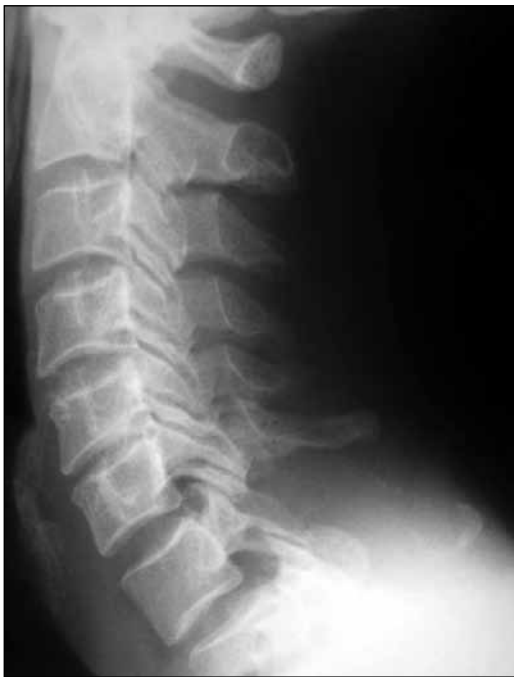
Plain X-rays of cervical spine showed a destructive lesion that affected the lamina and spinous process of C7 vertebra.
